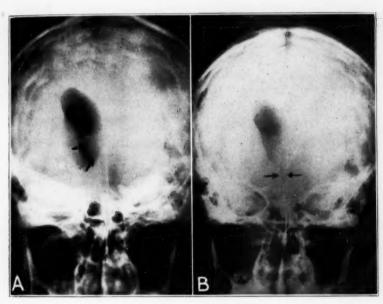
(case 2).—Anteroposterior roentgenogram showing the hemispheric shadow of the paraphysial cyst impacted in the left foramen of Monro and in B the small bubble of air in the undisplaced third ventricle, making unlikely the presence of a glioma or of a cyst of the cavum Vergae.
